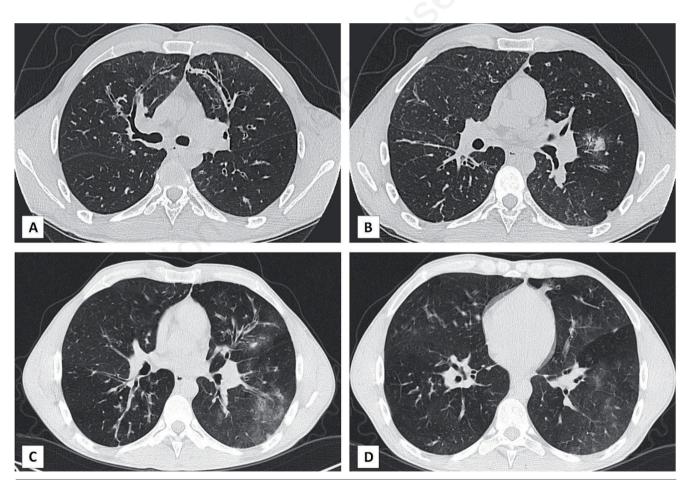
Chest computed tomographic images. A) Axial unenhanced chest CT performed on day of admission showed typical alterations of cystic fibrosis characterized by upper-lung-predominant cylindrical bronchiectasis with mucus plugging and bronchial wall thickening. B) CT images also confirmed a consolidation lesion in the lower left lobe and subpleural ground glass opacities. C,D) Follow-up CT scan performed after 14 days of hospitalization showed the resolution of the previous parenchymal consolidation while ill-defined patchy ground-glass opacities increased in the lower left lobe and in the lingula.
